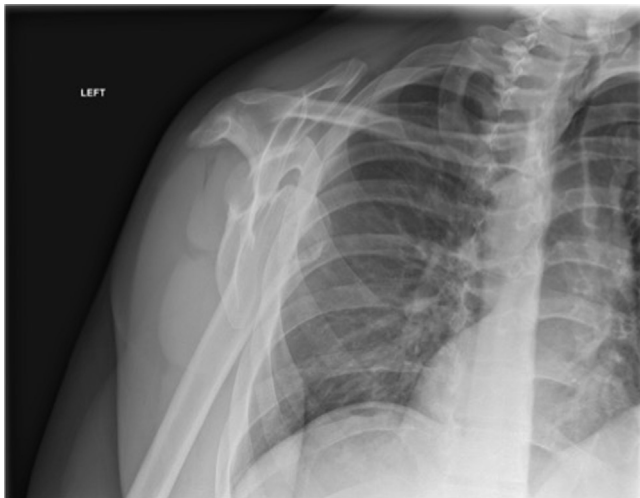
Scapular Y X-ray of the left shoulder demonstrating anterior glenohumeral joint dislocation.
